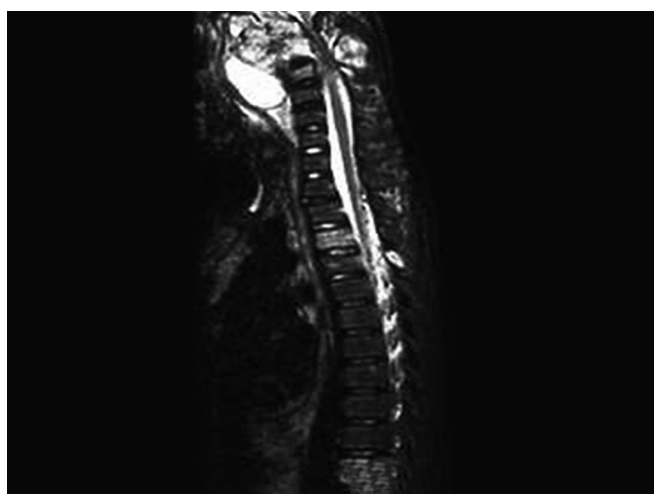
MRI of dorsal spine (sagittal section) showing the involvement of vertebral body by tuberculosis (central TB).
